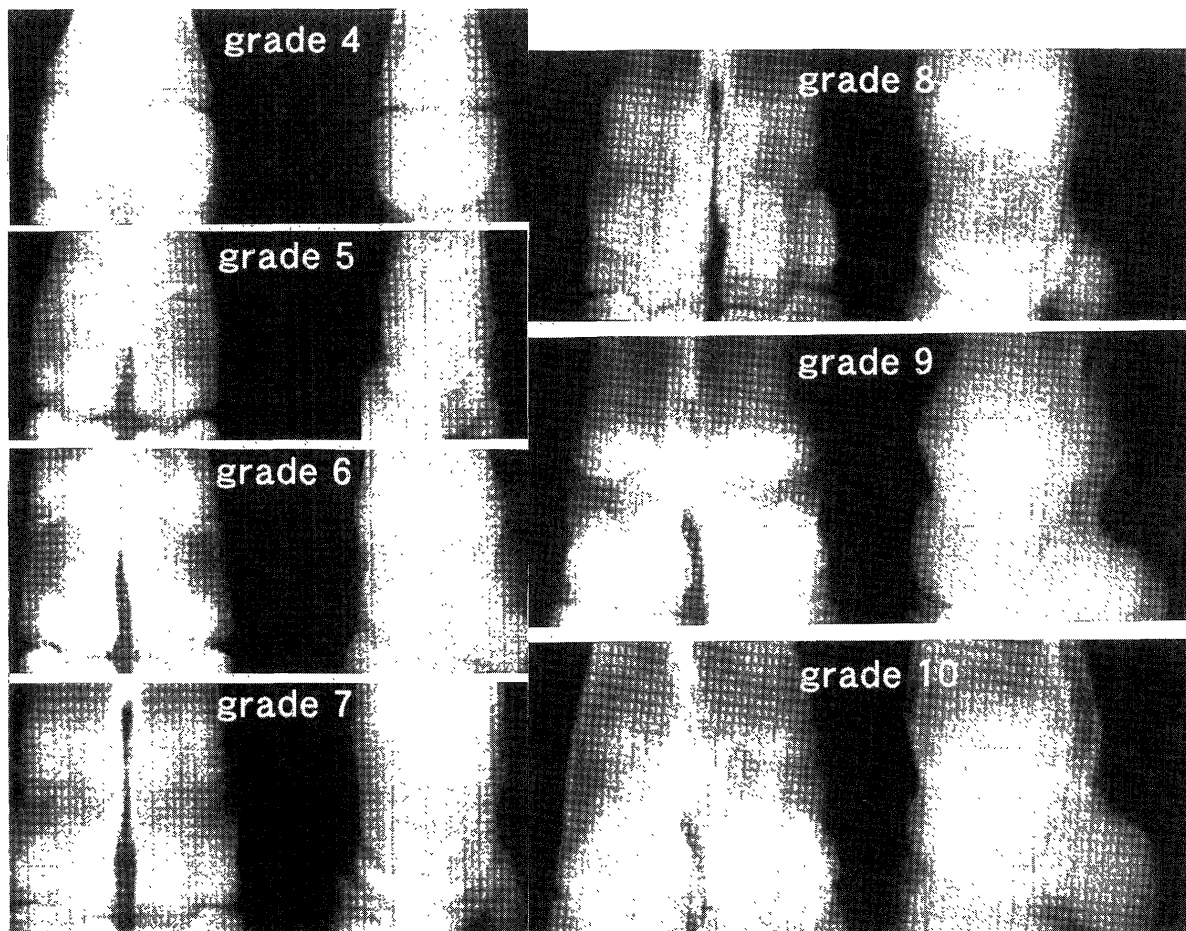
Radiographs of standard ossification in the distal metacarpus. Immediately after birth, the ossification stage was grade 4 or 5. Grades 6, 7, 8, 9 and 10 were found at 1, 2–3, 4–10, 11–18 and 19–23 months of age, respectively.
